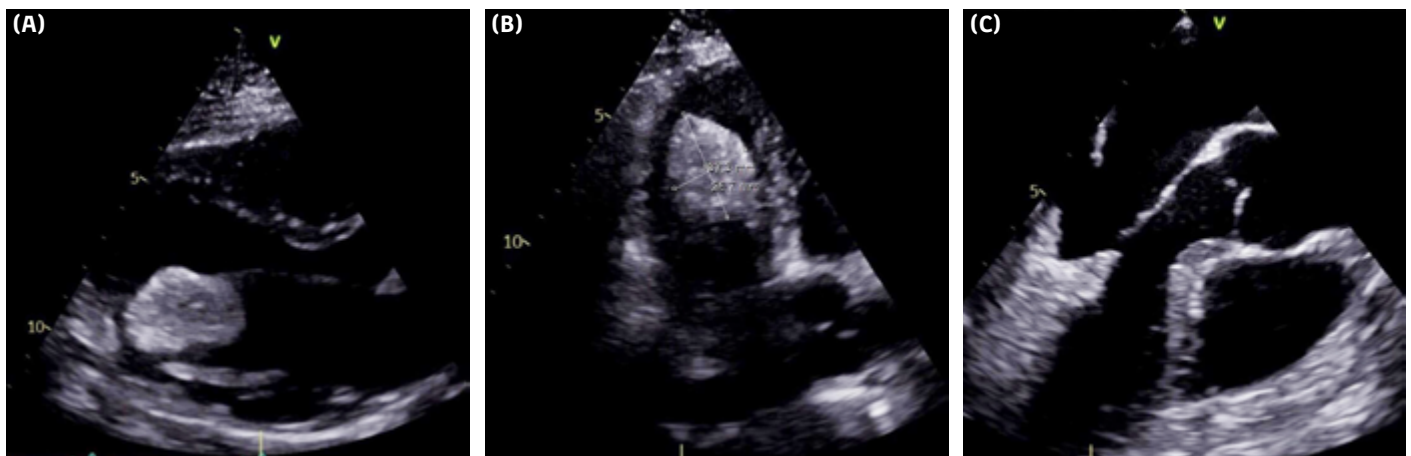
Transthoracic (A, B) and transesophageal echocardiographic (C) views. (A) Parasternal long-axis view; (B) Apical four-chamber view; (C) 135° view.
